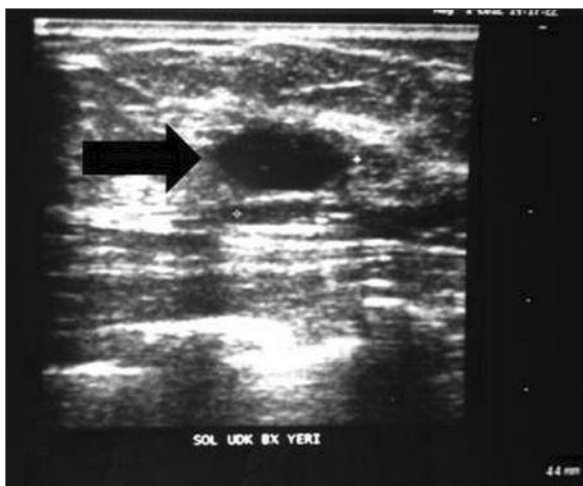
Ultrasonography of breast shows a heterogeneous hypoechoic mass measuring 10x14 mm with irregular contours which had fibrotic shrinkage around.
